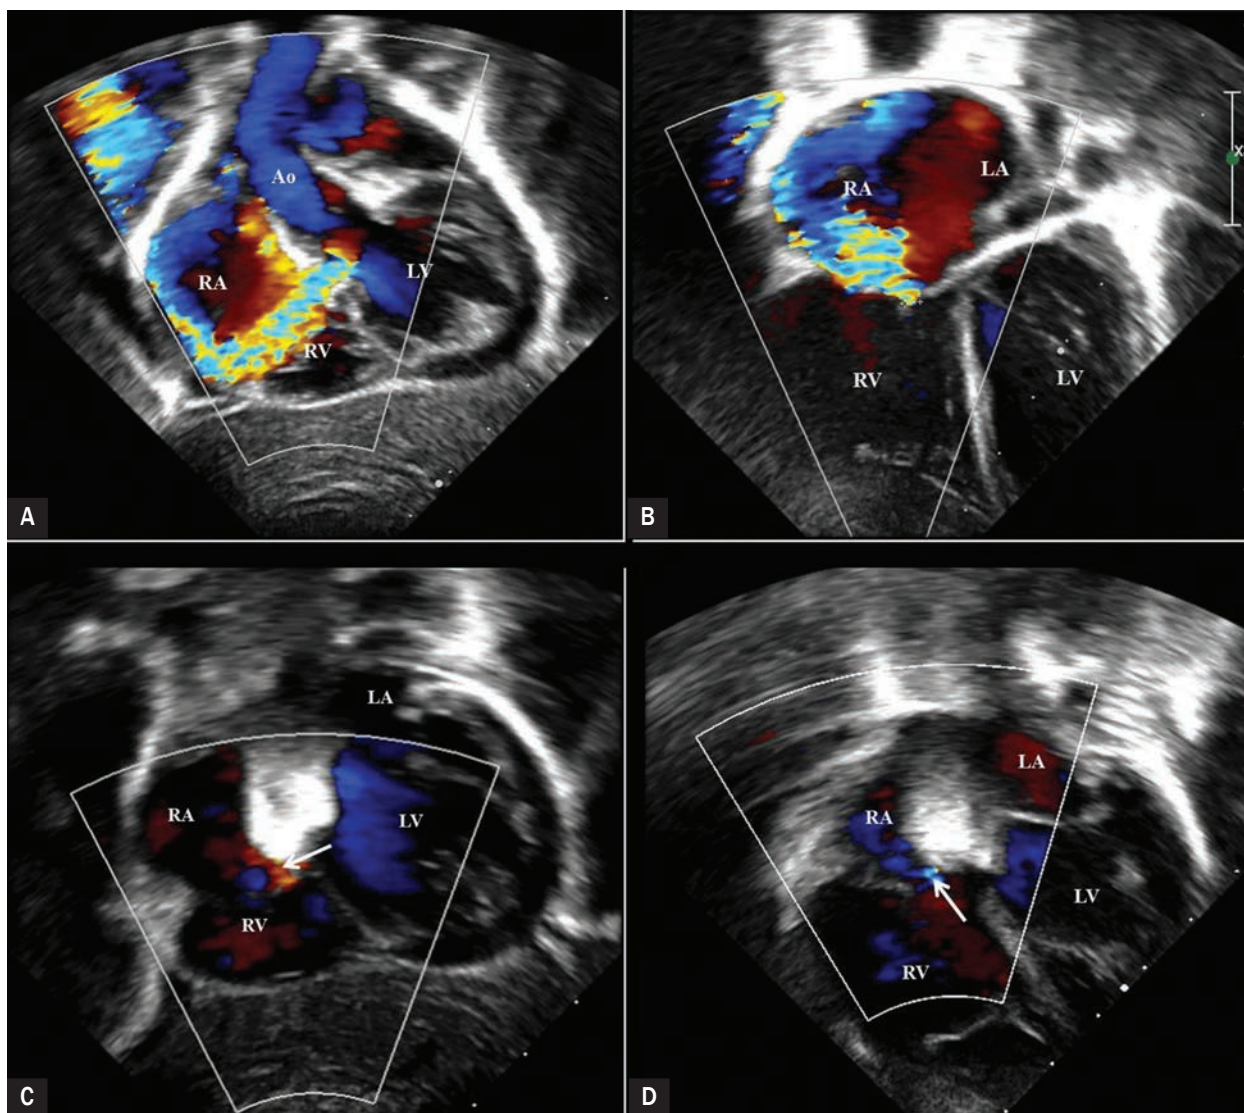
Transthoracic echocardiography image of native, true Gerbode shunt coexisting with significant tricuspid regurgitation in an infant before; C, D. After closure with Nit-Occlud Lê VSD device. A. A subxiphoid view of the congenital, direct left ventricle-to-right atrial shunt in an 8-month-old infant before the procedure; B. Four-chamber view of the same patient showing regurgitation of the tricuspid valve, due to prolapsing of the septal leaflet. No shunts below the septal leaflet of the tricuspid valve were seen; C. A subxiphoid transthoracic echocardiography projection demonstrating mild, residual shunt (white arrow) after the closure of true Gerbode defect with Lê VSD-Coil (a bright hourglass-like shadow); D. A four-chamber view showing trivial retrograde flow across the tricuspid valve after the procedure in this patient; VSD – ventricular septal defect
